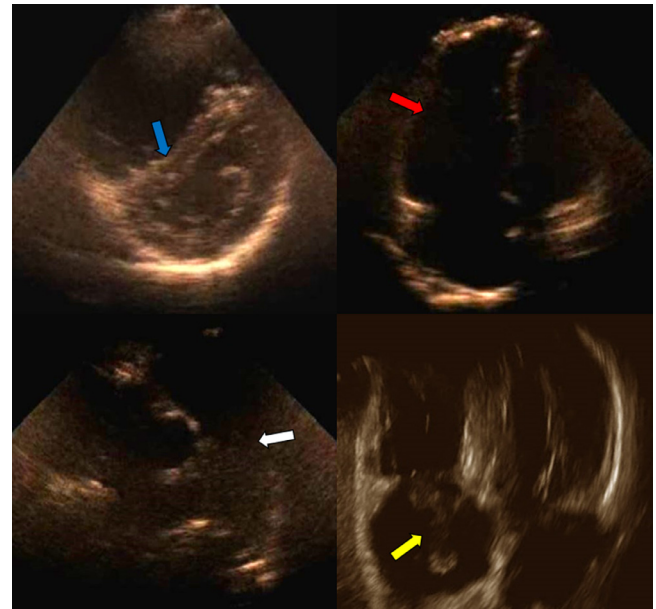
The transthoracic echocardiography of the patient. The blue arrow shows D-shape left ventricular; the red arrow shows right ventricular enlargement; the white arrow shows main pulmonary artery enlargement, and the yellow arrow shows a large right atrial clot.
